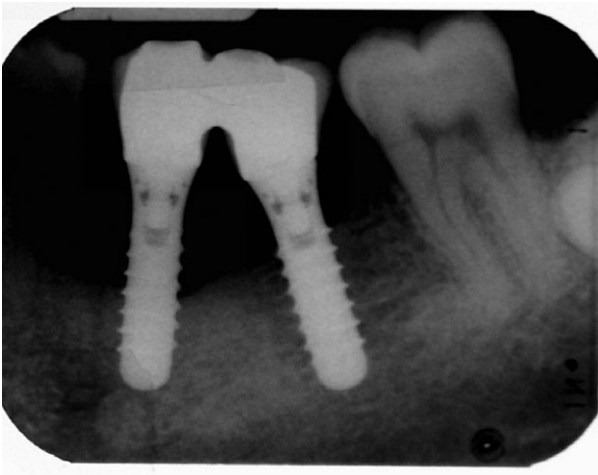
Bone loss around implants: radiograph of implants with horizontal bone loss.
